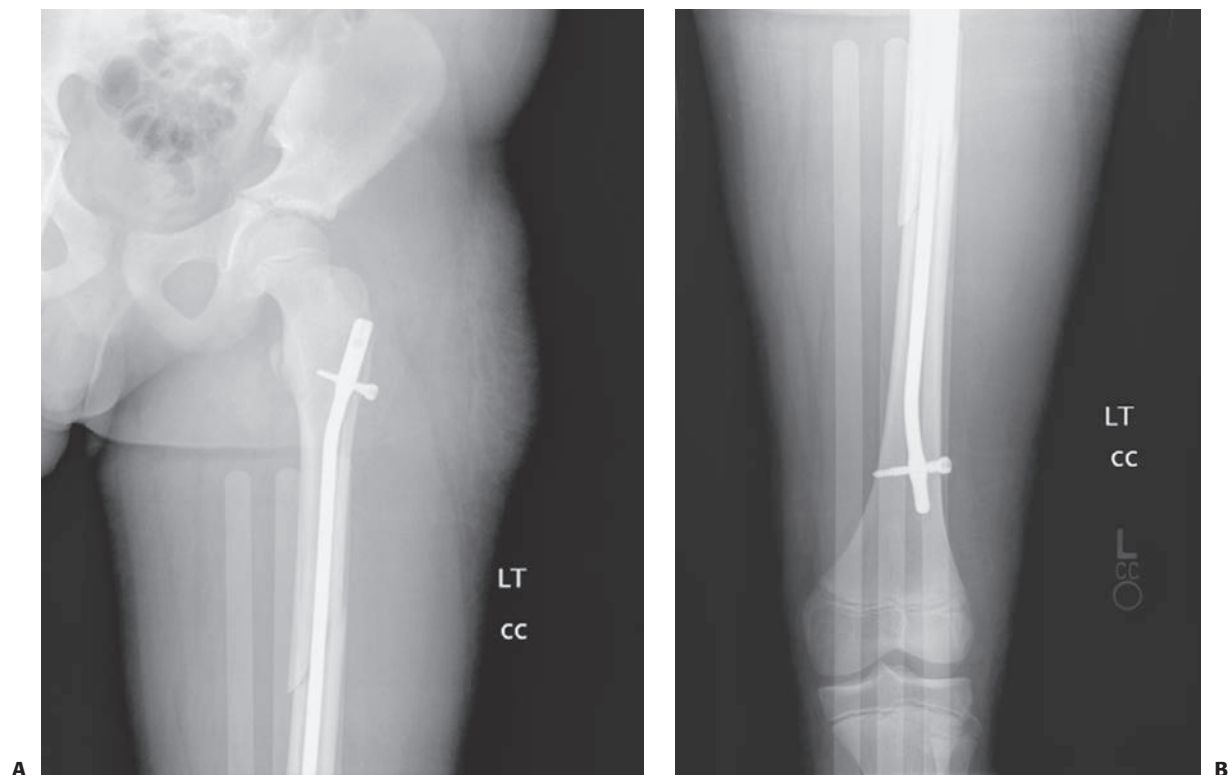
AP (A) and lateral (B) radiographs immediately after internal fixation of the midshaft femur fracture in a 13-year old with a pediatric locking nail that permits easy lateral entry, and requires minimal reaming of the child's proximal femur.
